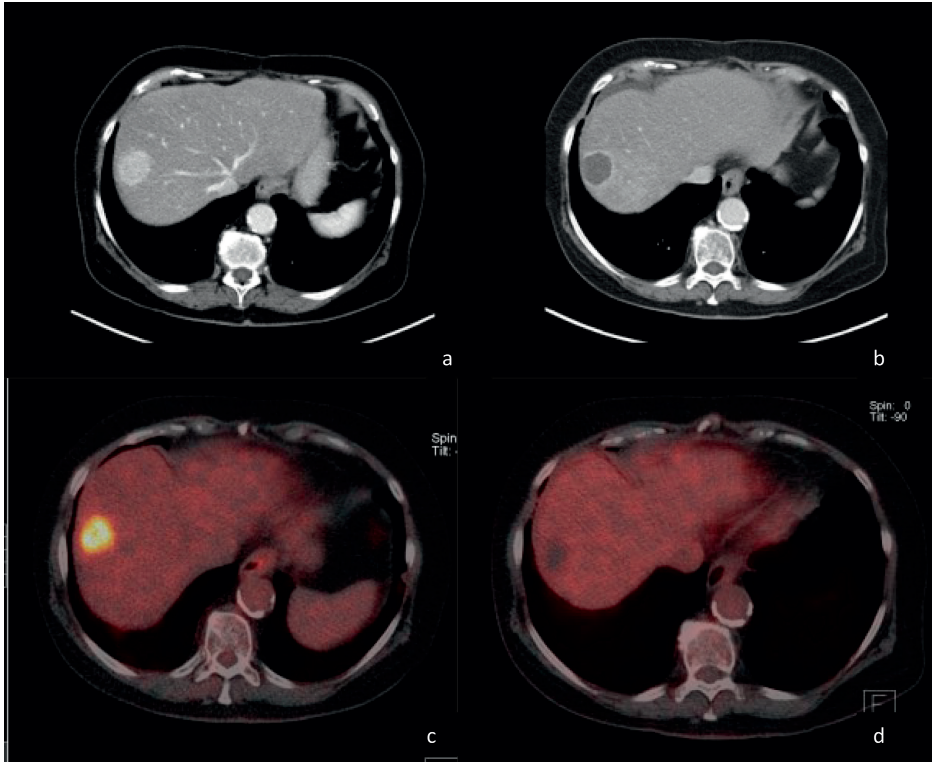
Figure a shows a contrast-enhanced CT image of a metastasis of an intrahepatic cholangiocarcinoma in a 80-year-old woman. Figure b shows a contrast-enhanced CT image of the same metastasis 3 months later, after treatment with radioembolization (120 Gy Theraspheres). Figure c shows a baseline PET/CT image of the same metastases. Figure d shows a PET/CT image of the same metastasis 3 months after treatment.
